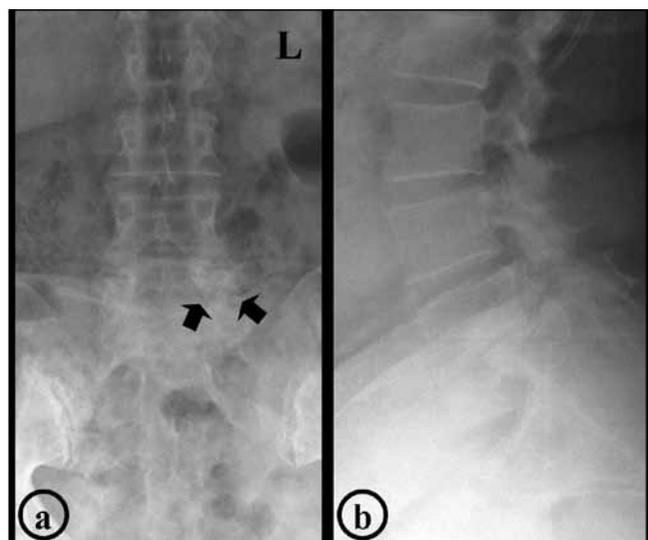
A) Anteroposterior radiograph of the lumbosacral spine shows existence of two separate facet joints on the same side (black arrows); B) Lateral radiograph of lumbosacral spine shows Grade II L5-S1 spondylolisthesis.
